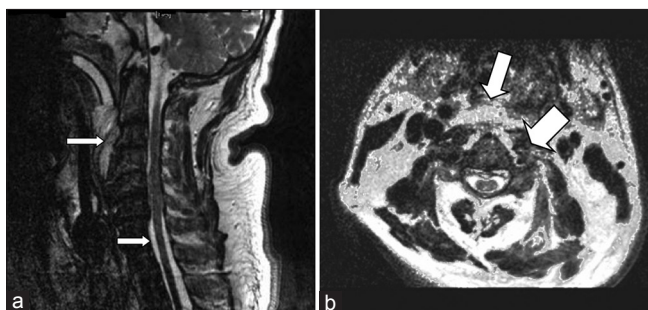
Prevertebral and epidural abscess on preoperative magnetic resonance imaging. (a) Sagittal view (b) Axial view
